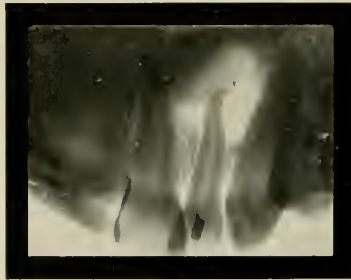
Alveolar abscess wrongly diagnosed as pyorrhœa. (Radiograph by Rhein, of New York.)
